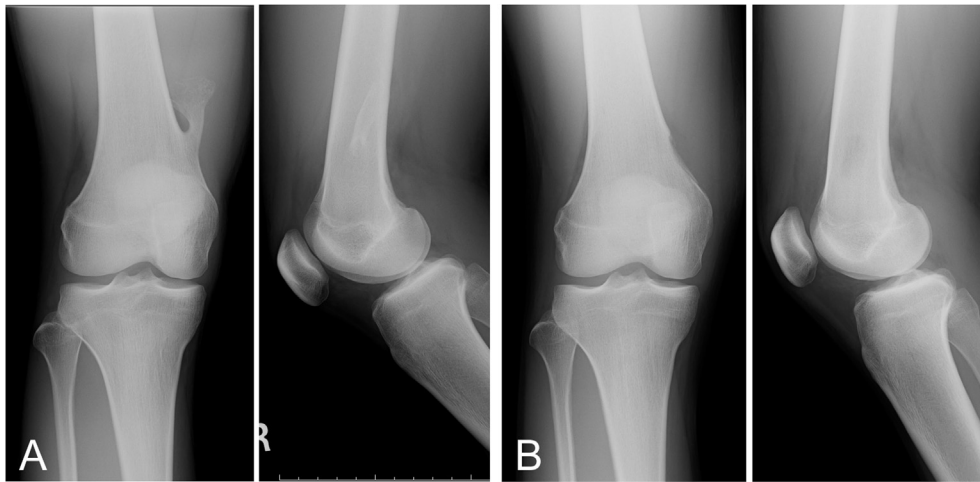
A 19-year-old male with a subvastus osteochondroma in the distal femur. Plain radiographs show a lesion protruding from the distal femur (A). A resection is performed (B) (Left: antero-posterior view; Right: lateral view).
